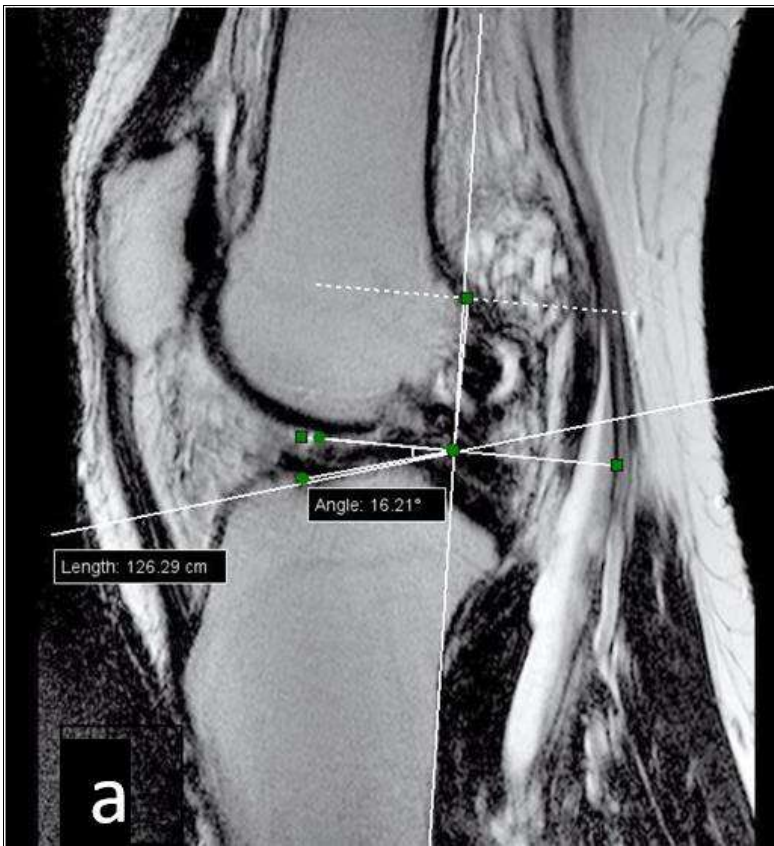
Partial ACL tear in contact injury- Tibial slope angle measured on midsagittal section on MRI. The angle in this measure 15o.
